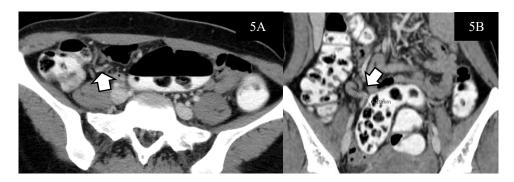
A 31-year-old female presented with RLQ pain and partial antibiotic drug treatment for 3 days. Axial (A) and coronal (B) contrast-enhanced CT images with positive rectal contrast administration show normal diameter of the appendix (arrow) without definite enhancement or fat stranding, the diameter is
